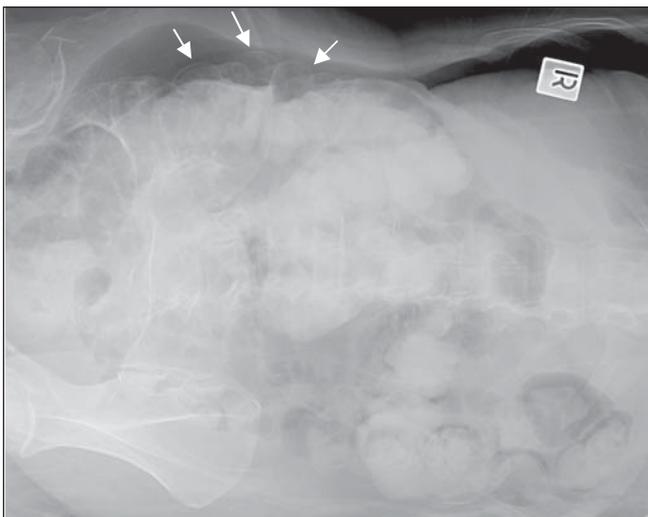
Left lateral decubitus abdominal radiograph demonstrating a large amount of free air and multiple cysts along the bowel wall (arrows).
